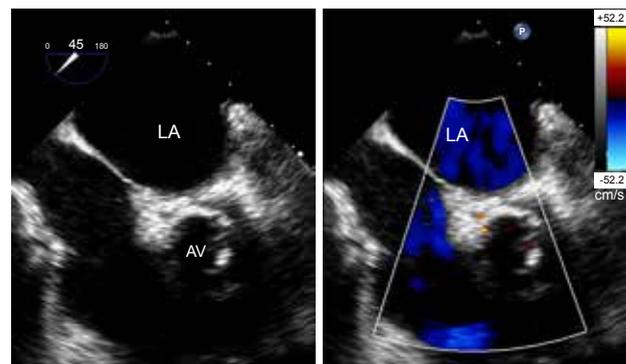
Two-dimensional transesophageal echocardiogram at the level of the aortic valve (AV) with color flow at mid-diastole, demonstrating a small residual paravalvular defect with trivial flow. LA – left atrium.
